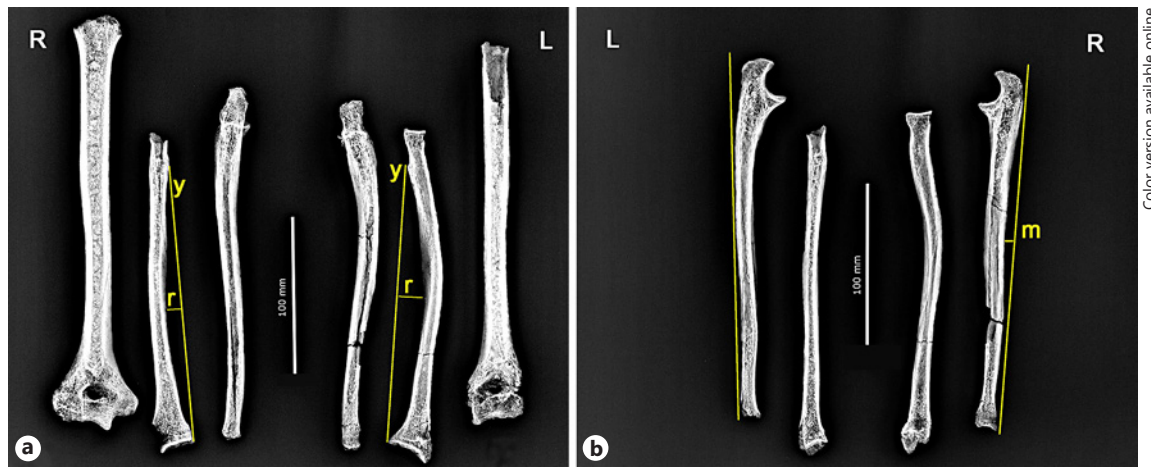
Radiograph of the upper limb long bones. a A-P projection. *y*, distance from the bicipital tuberosity to the distal radial epiphysis; *r*, line at maximum bow. b Lateral projection. *m*, bowing of the ulna.
